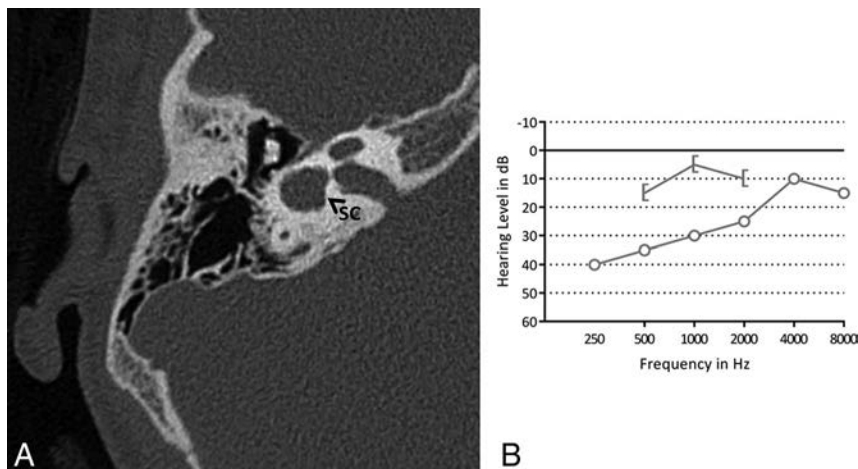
A, Axial CT image of the right mastoid bone. The bony island of the lateral semicircular canal is missing, and the canal and vestibule are composed of a single cavity (SC). B, A pure tone audiogram of the same ear shows conductive hearing loss, more pronounced in the low frequencies. The circle indicates an unmasked air-conduction threshold; the bracket, a masked bone-conduction threshold.
